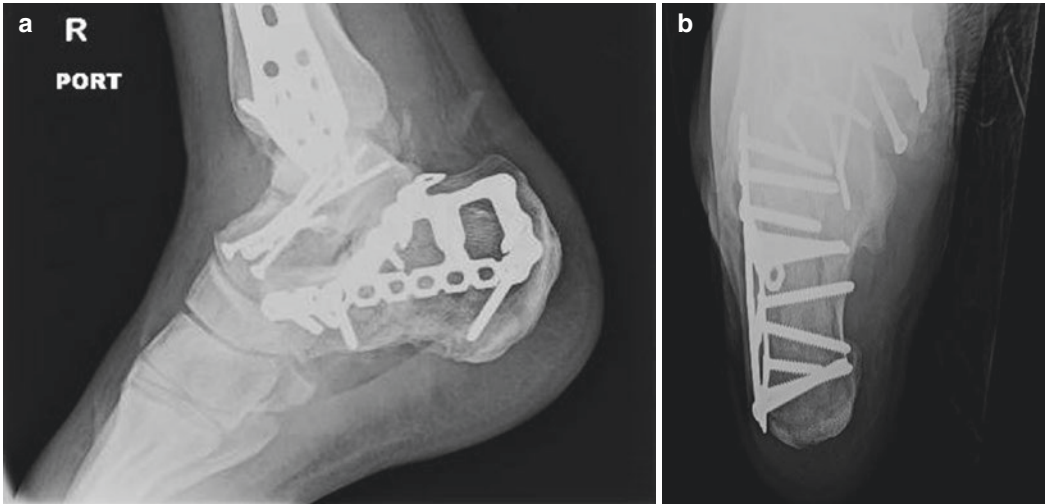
A lateral (a) and AP (b) X-ray demonstrating final fixation of the pilon, talus, and calcaneus fractures seen in Fig. 22.6a,b
